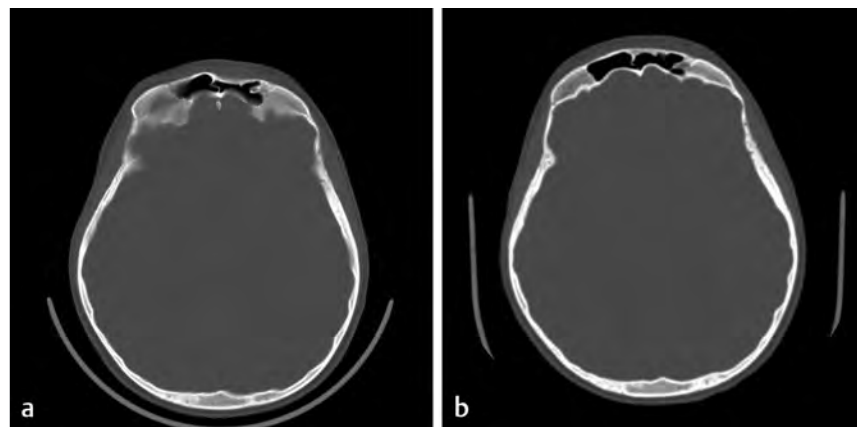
Anterior table frontal sinus fracture remodeling. (a) A patient with depressed anterior table frontal sinus fracture, without a posterior table fracture or injury of the nasofrontal outflow tract, who presented for plastic surgical evaluation 4 weeks after the injury. The family wished to avoid surgery, and a conservative follow-up course was adopted. (b) One-year follow-up CT scan revealed remodeling of the anterior table without contour irregularity and the absence of retained fluid in the sinus. An additional follow-up with repeat imaging 5 years after the injury was recommended to ensure that the patient had a “safe sinus.”
